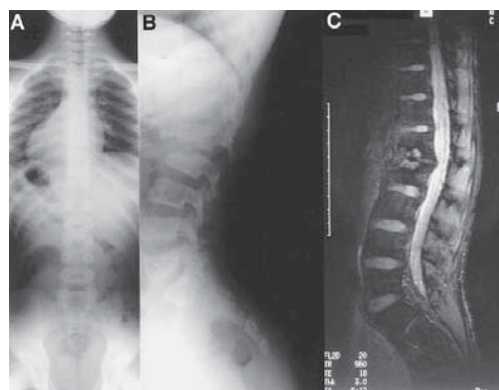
Anteroposterior (A) and lateral (B) radiographs and sagittal MRI view (C) of the spine, demonstrating a destructive lesion involving the L1 and L2 vertebral bodies and the L1–L2 disc. There is no evidence of scoliosis.
